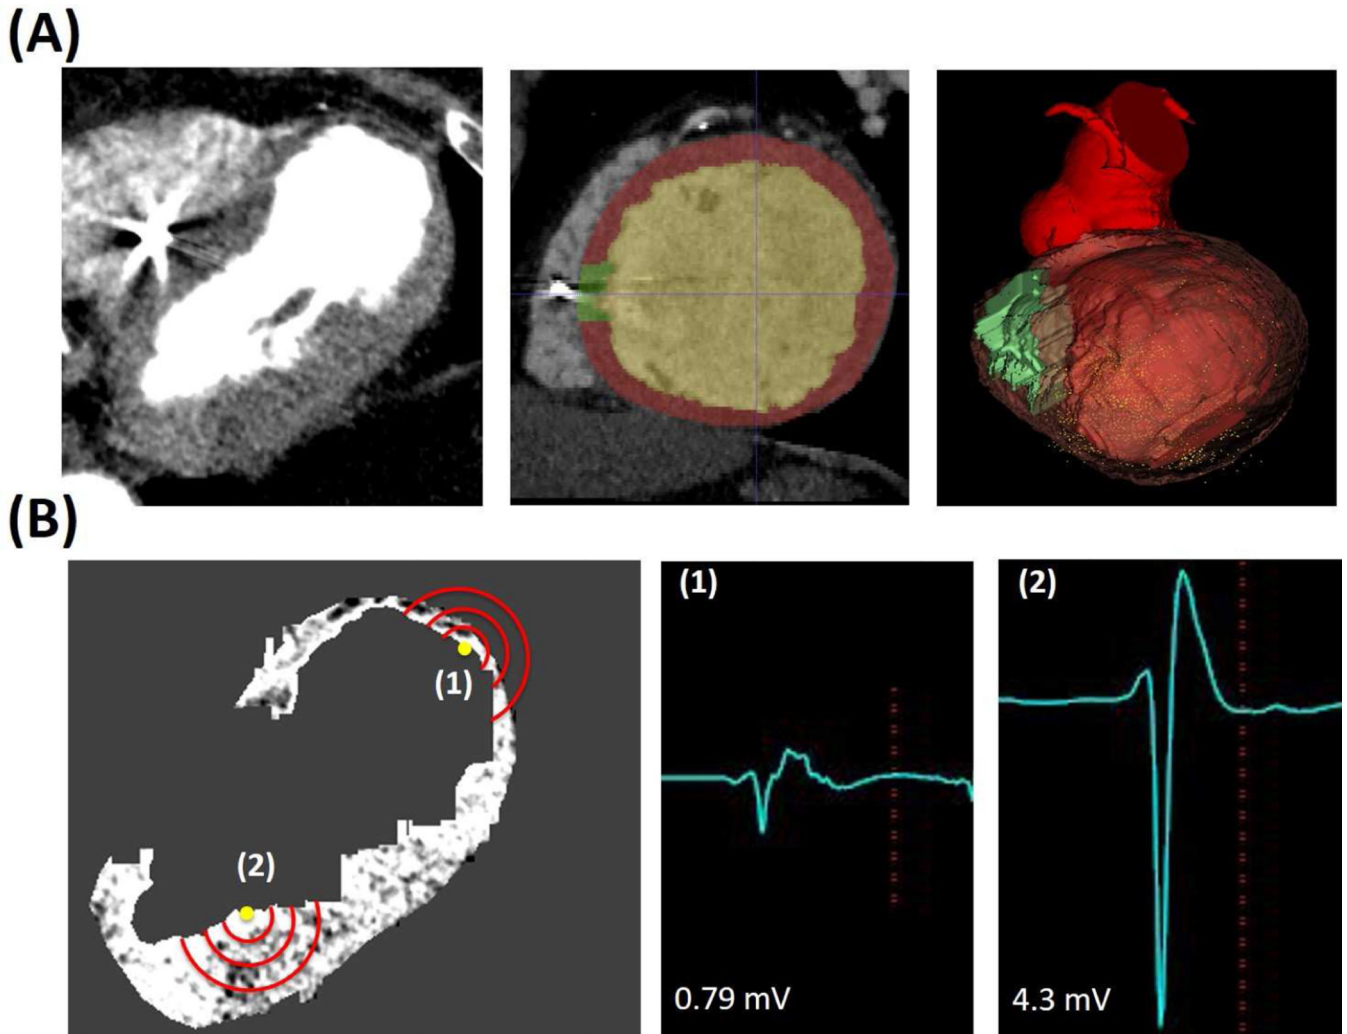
Registration of CE-CT to Electroanatomic Map and Field of View Analysis
